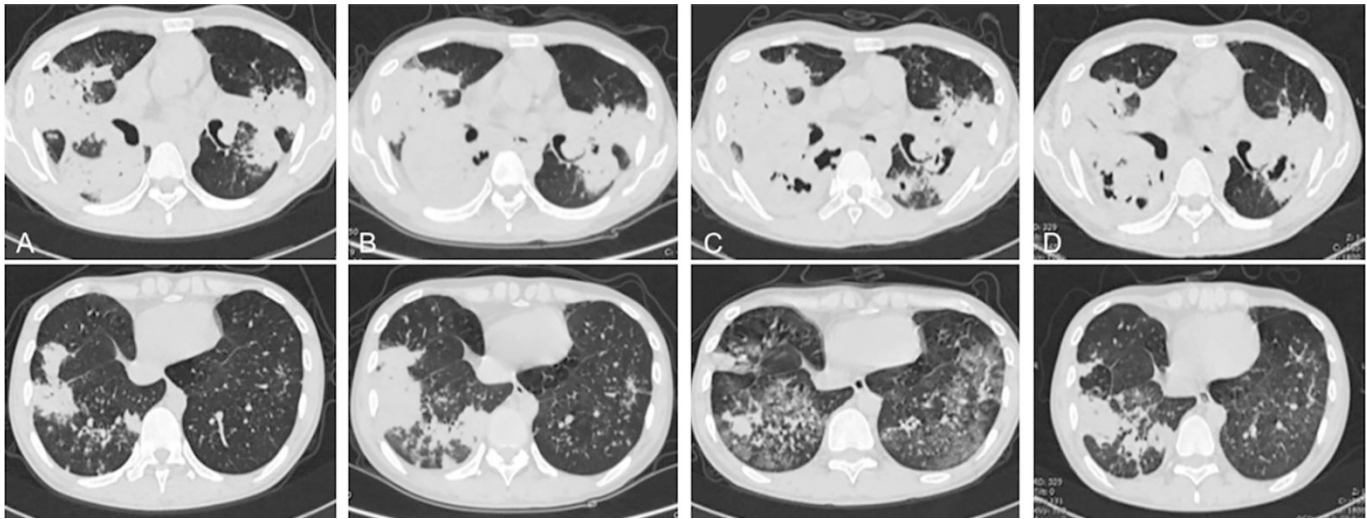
Comparison of chest CT tests on 15 March (A), 29 March 29 (B), 6 April (C), and 28 April (D), 2021.
